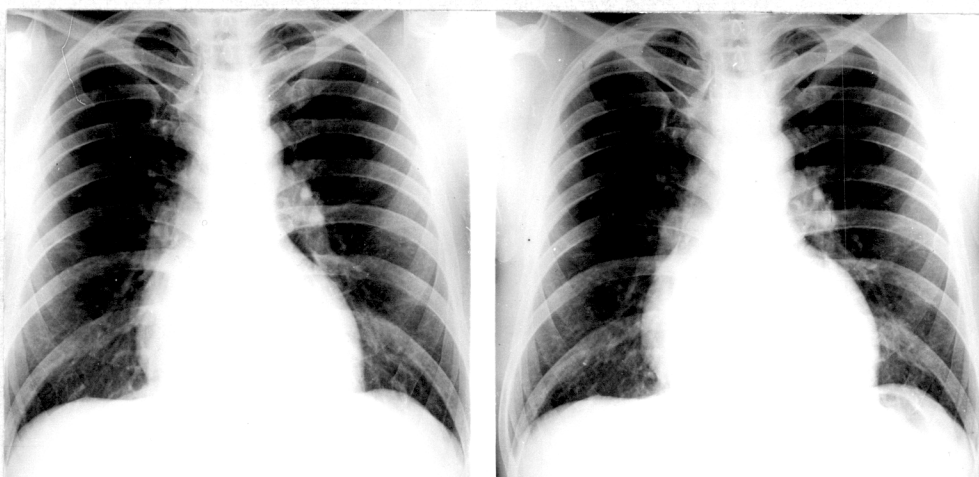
Chest radiograph of Patient number 102, in atrial fibrillation on the left and sinus rhythm on the right. The CTR is 48% in atrial fibrillation and 53% in sinus rhythm.
